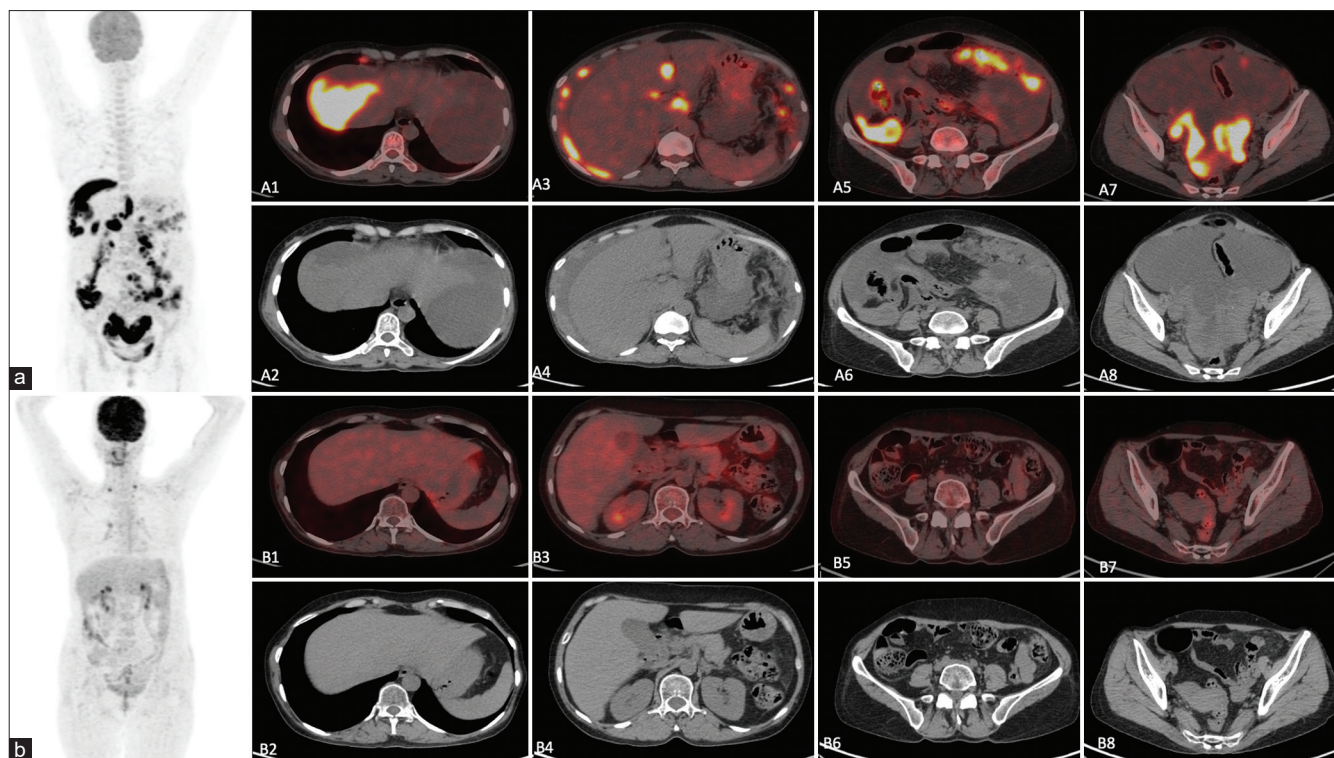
For NACT response evaluation. A 46-year-old female presented with complaints of pain abdomen, abdominal distension, loss of appetite, and nausea and vomiting for 3 months; Serum CA 125 levels were 920 U/ml. A baseline 18F-FDG PET-CT study was ordered; MIP images (a) and transaxial fused PET-CT (a1, a3, a5, and a7) and CT images (a2, a4, a6, and a8) showed hypermetabolic solid-cystic masses involving bilateral adnexa along with multiple peritoneal and serosal deposits, moderate-to-gross ascites, omental caking, and anterior diaphragmatic lymph nodes. Biopsy from the adnexal mass showed a high-grade serous carcinoma. The patient received four cycles of NACT followed by response evaluation with 18F-FDG PET-CT scan. The MIP images (b) and transaxial fused PET-CT (b1, b3, b5 and b7) and CT images (b2, b4, b6, and b8) showed no metabolically active residual disease in the body with resolution of previously noted bilateral adnexal masses, peritoneal, omental and serosal deposits, omental caking, abdominal and pelvic ascites, and right anterior diaphragmatic lymph nodes, suggestive of a complete metabolic response. The patient's serum CA 125 levels at the time of the second PET-CT study was 6.9 U/ml (normal <35 U/ml). PET/CT: Positron emission tomography/computed tomography, FDG: Fluorodeoxyglucose, NACT: Neoadjuvant chemotherapy
